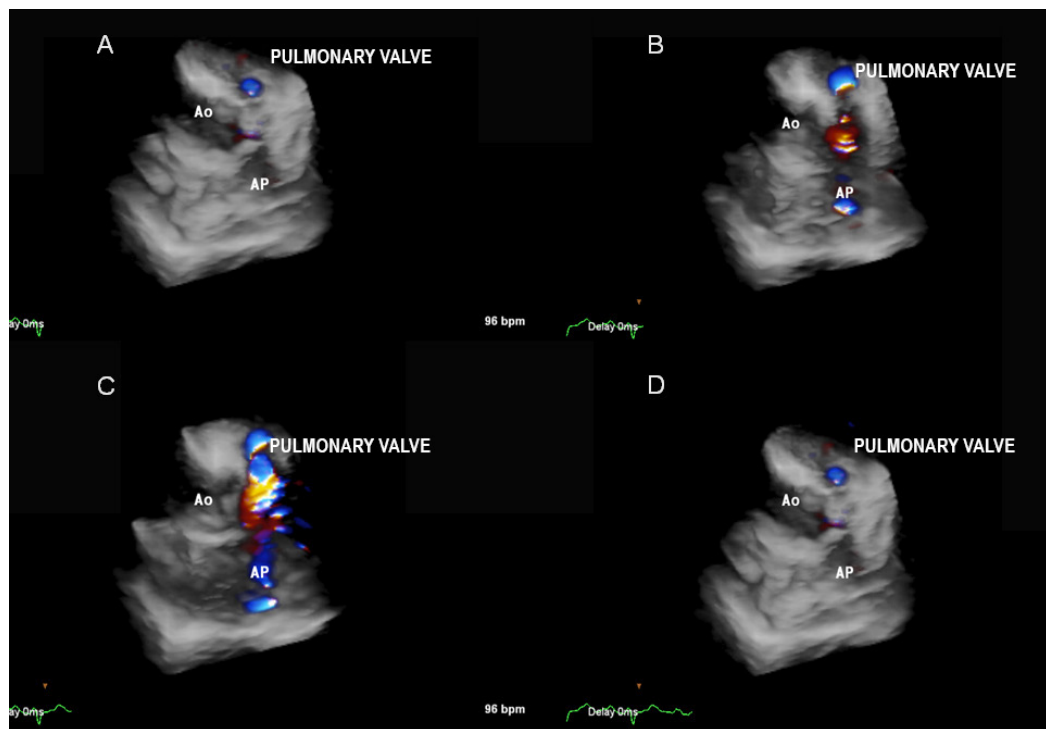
Real-time three-dimensional transthoracic echocardiography with right ventricular outflow tract mapping and pulmonary valve in four moments of the cardiac cycle, showing valve stenosis with slight valvar regurgitation associated. A: late diastole; B: pulmonary valve opening; C: systolic peak; D: early diastole.
